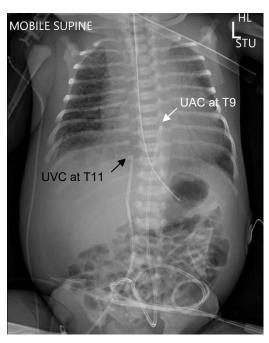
Demonstrating UAC position on x-ray.
